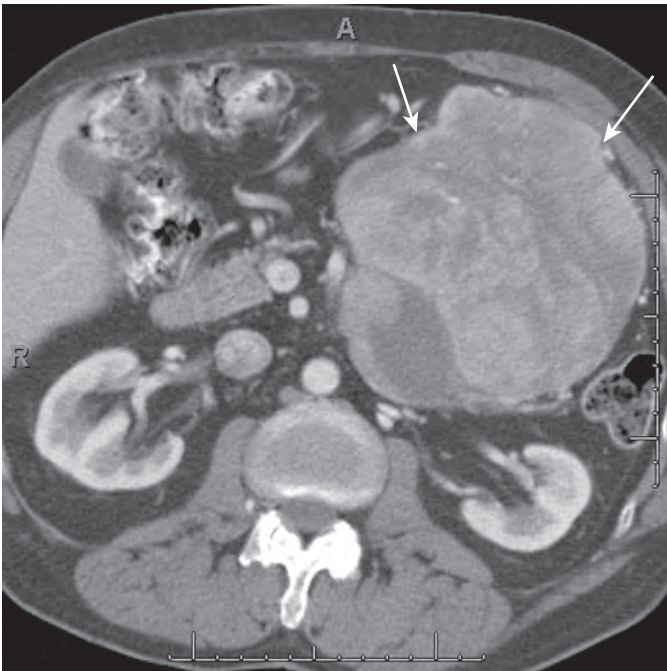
Fibrosarcoma. Axial CT demonstrating a heterogeneously enhancing fibrosarcoma in the mesentery (arrows).
